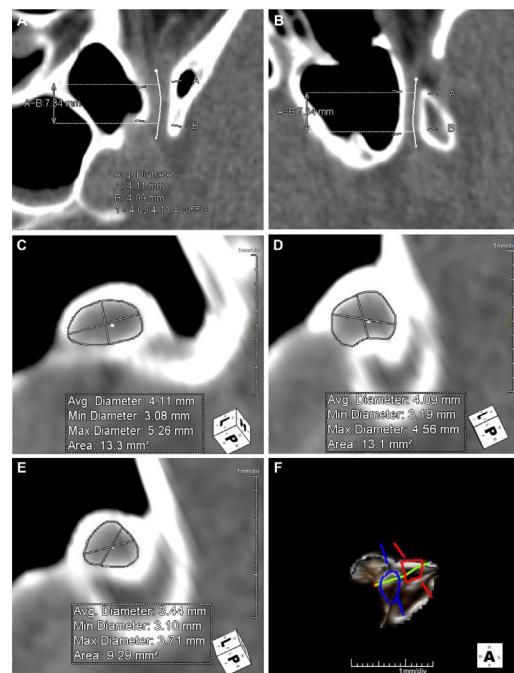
TeraRecon analysis of sinus CT images. (A) The midline is manually traced on the transverse plane using freehand tool. (B) The midline is corrected on the sagittal plane. (C) Point A is established as the beginning of estimated 75% osseous enclosure. (D) Point B is established as the end of estimated 75% osseous enclosure, subsequently producing optic canal length as distance between point A and point B on the transverse and sagittal views. (E) minimum cross-sectional area is established by tracing the cross-sectional area on each slice from point A to point B. The minimal diameter at the smallest cross-sectional area is also established. (F) Reconstructed three-dimensional optic canal is shown; blue tracing represents point A, red tracing represents point B and centre line is shown in green. Of note, figure 1F shows reconstruction for a different optic canal as shown in figure 1A through figure 1E. Small boxes in the lower right-hand corner show orientation. A, anterior; avg, average; F, feet; H, head; L, left; P, posterior; R, right.
